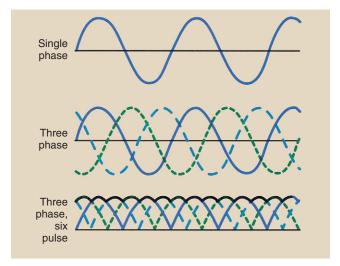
Three-phase power is a more efficient way to produce x-rays than is single-phase power. Shown are the voltage waveforms for unrectified single-phase power, unrectified three-phase power, and rectified three-phase power.
